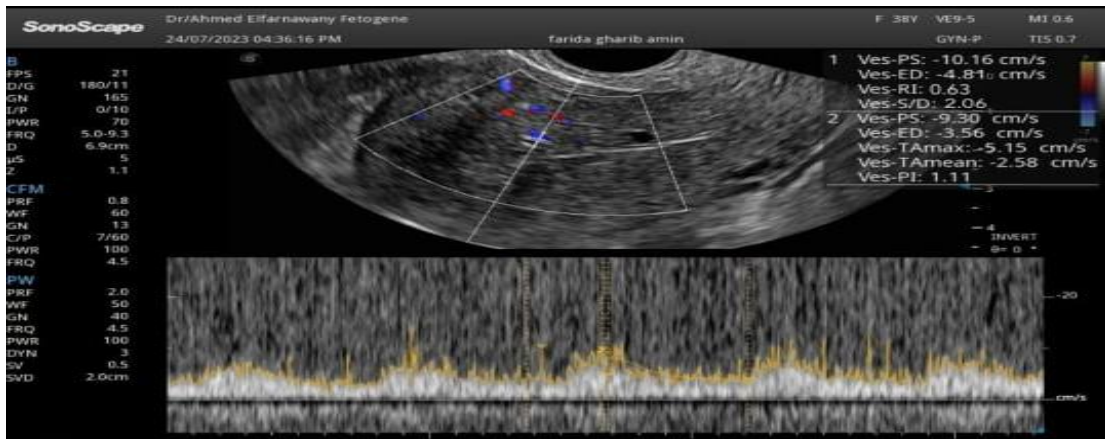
Uterine artery Doppler results of a case who failed to get pregnant after ICSI.
